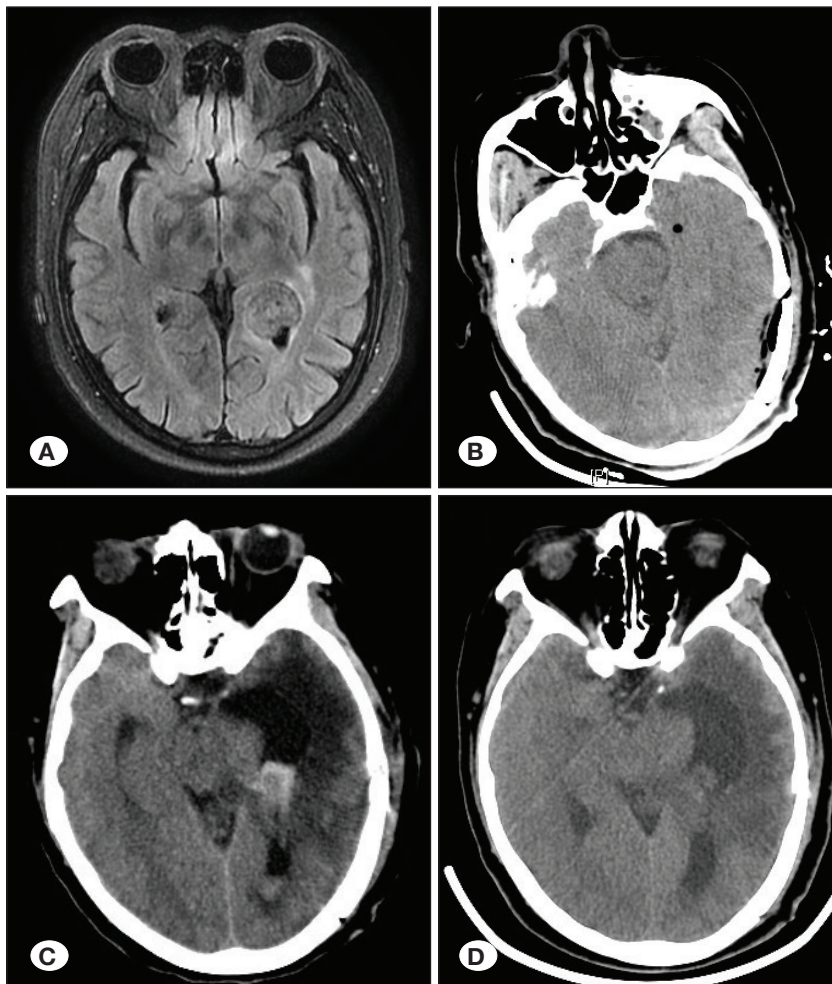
A) Preoperative axial MRI. B) CT re-examination on the day following operation. C) CT re-examination of CT postoperative day 7. D) CT re-examination before discharge on postoperative day 20.
